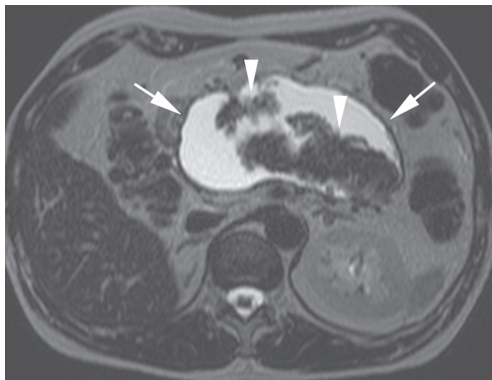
A 50-year-old man with extensive necrosis and mild clinical symptoms. MRI was performed for continuing mild discomfort 6 weeks after an episode of acute pancreatitis. T2-weighted sequence shows a fully encapsulated collection (walled-off necrosis) in the pancreatic area (arrows) with dark material (arrowheads), representing necrotic pancreatic and peripancreatic tissue.
